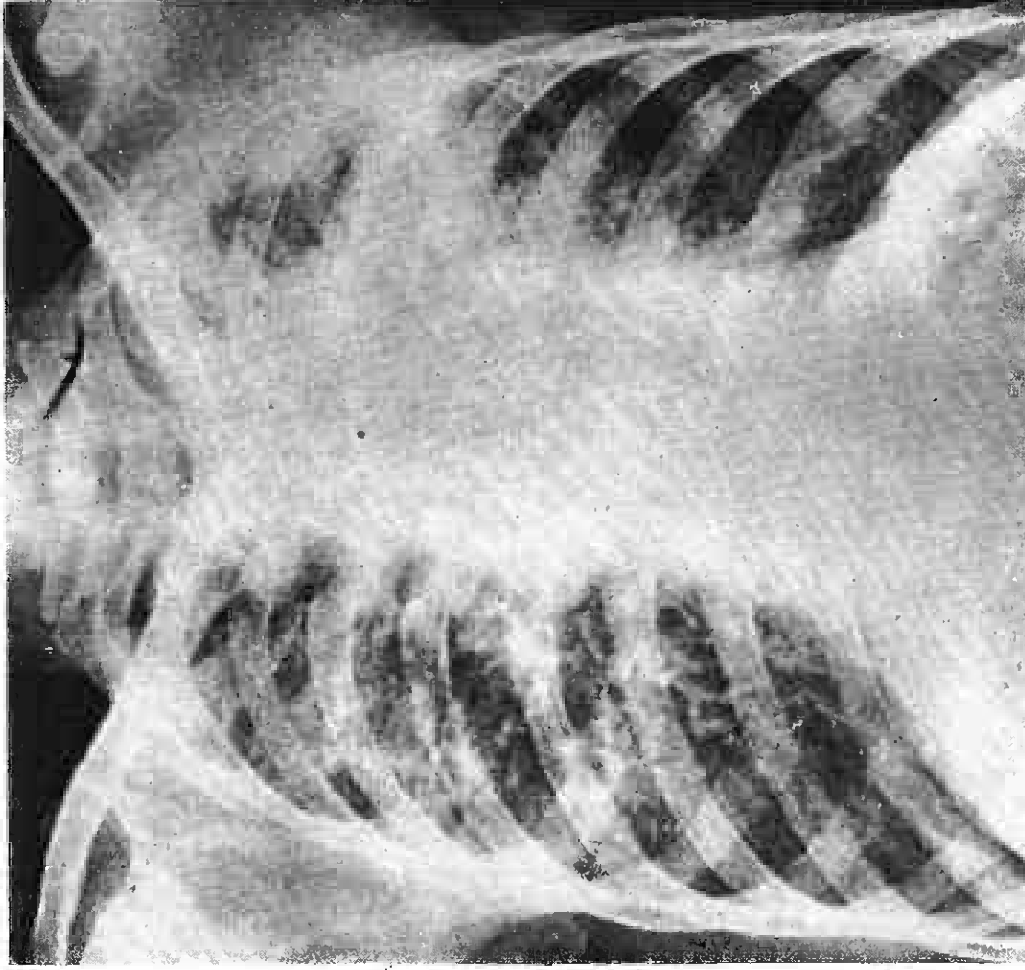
Case 10. Chest X-ray film taken on 22nd October 1960. He had begun treatment in Tan Tock Seng Hospital in April 1960 as a case of Silico-tuberculosis and by 13th October 1960 had completed 150 Gm. of Streptomycin. X-ray shows progressive massive fibrosis extending 3 anterior rib spaces on the left and 2 on the right against a background of mixed type of simple pneumoconiosis. Coded as 3 m. B2/3.
